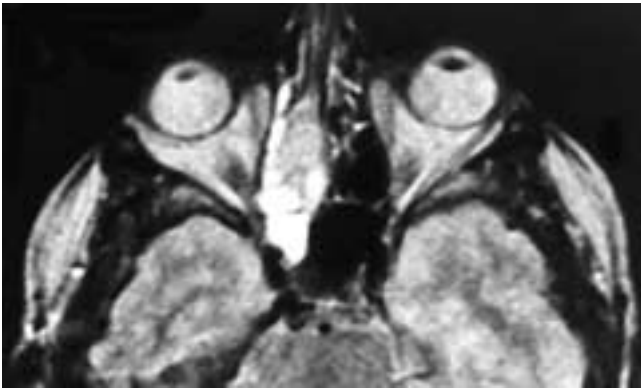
Axial proton density MR image shows a right ethmoid and nasal mass that has a low to intermediate signal intensity. Surrounding the mass are chronically obstructed secretions with high signal intensity. This is a nonspecific imaging appearance. This patient had an extramedullary plasmacytoma.
